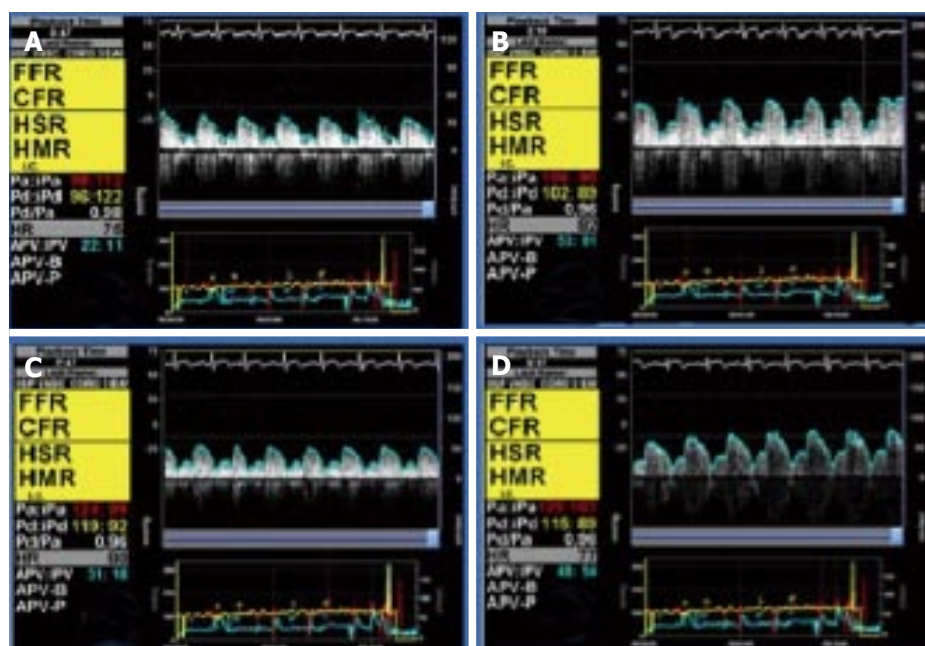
Microvascular function measured by intracoronary Doppler. A shows an intracoronary Doppler tracing at baseline condition, with an APV of 22 cm/s; B shows Doppler at the same position during maximal hyperemia, induced with an adenosine intracoronary bolus of 200 μ g, with an APV of 53 cm/s. CFR is therefore 2.4, indicating a normal endothelium-independent microvascular function; in C and D, increasing doses of intracoronary acetylcholine have been administered; the APV is compared with the baseline tracing to determine the degree of microvascular vasodilation induced by acetylcholine, which in this case is normal, suggesting a normal endothelium-dependent microvascular function. CFR: Coronary flow reserve; APV: Average peak velocity.
